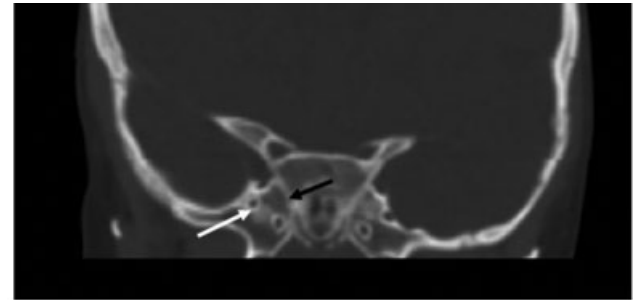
Coronal view (1.3 mm CT scan) of a representative image of a lateral craniopharyngeal canal in a 3 year old. The black arrow highlights the canal and the white arrow highlights the location of foramen rotundum
